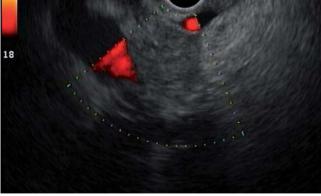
Endoscopic Doppler ultrasound image demonstrating invasion of the splenoportal confluence by the pancreatic mass, which generates a "stop" image on Doppler sign.
